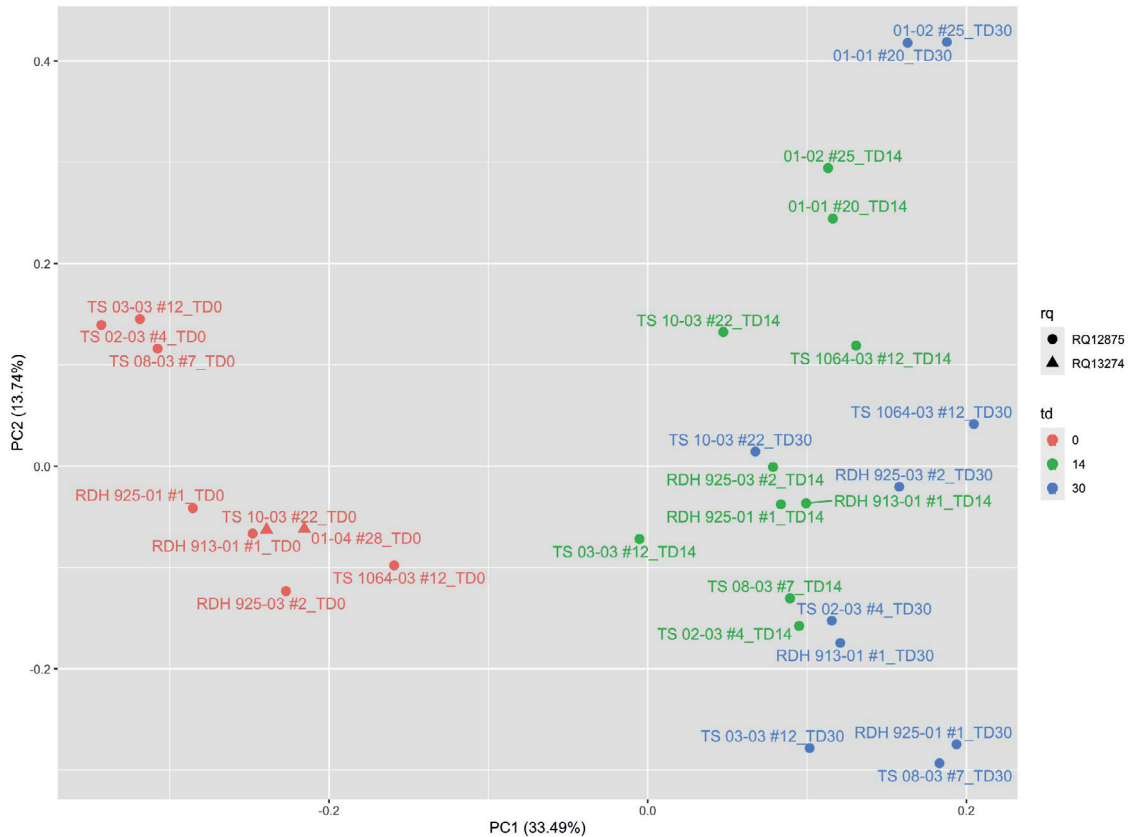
Principle Component Analysis (PCA) from RNA sequencing submissions shows no batch effect. Both submissions (submission 1: circle – RQ12875; submission 2: triangle – RQ13274) cluster similarly, with no obvious separation between samples attributed to separate submissions. PC1 (along X axis) shows that the strongest separation (33.49%) between samples is driven by time, as TD0 samples are sharply separated from TD14 and TD30 samples. PC2 (Y axis) shows that the next separation is attributed to individual background (TS vs CT); however, this separation is not as strong. These trends follow typical findings from patient and control PCA.
